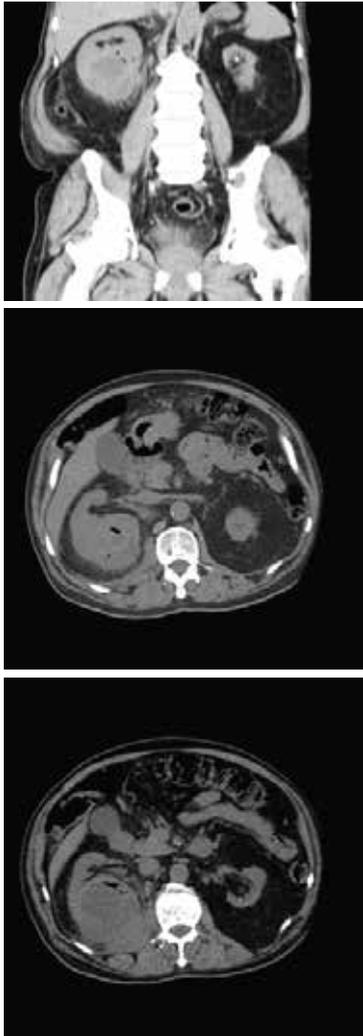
CT images showing the collection with air pockets, perinephric extension and perirenal inflammatory changes around the right kidney. Left kidney is contracted with calculus.
